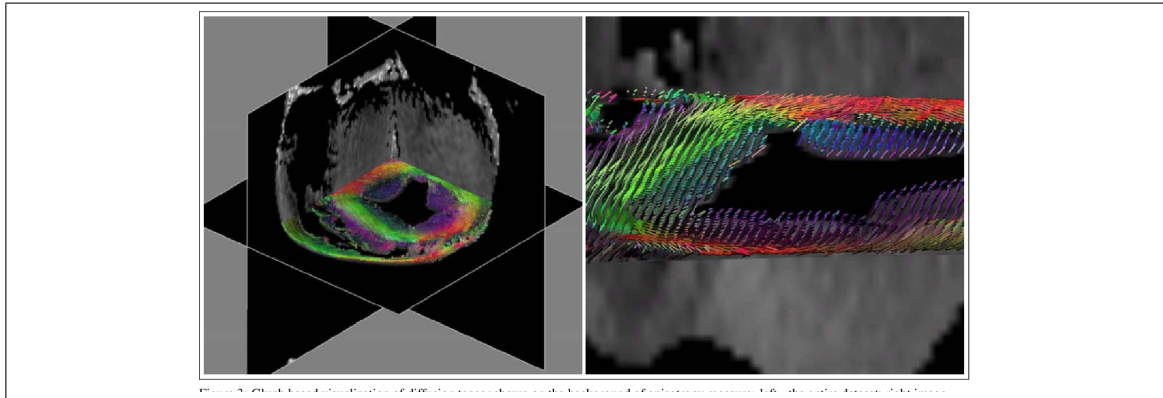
visualization of DT-MRI reconstruction of a heart (left) and zoomed view (right) showing the components of the fibers direction in colors. Taken from (Zhukov & Barr, 2003)
